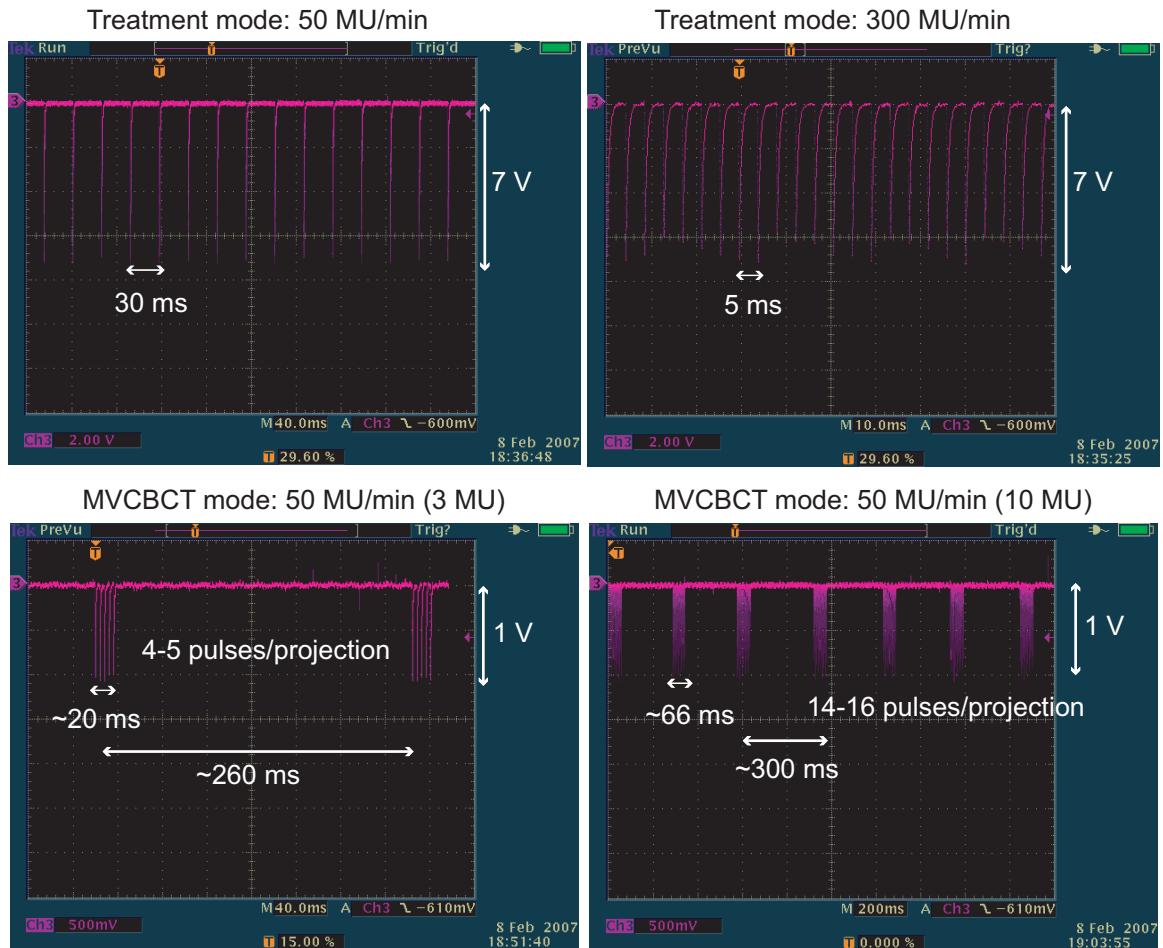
Beam electron pulses for treatment and MVCBCT dose delivery modes. A dose rate of 50MU/min is used for MVCBCT only when the beam is on. The gantry speed is adjusted to deliver the required number of electron pulses per projection in order to achieve the total dose specified in the MVCBCT protocol.
